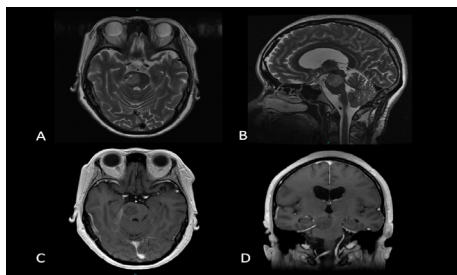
Two months after treatment of case 2. A, B: T2WI. C, D: Contrast MRI. The tumor in the brainstem is smaller than before, and contrast enhancement is poor.
